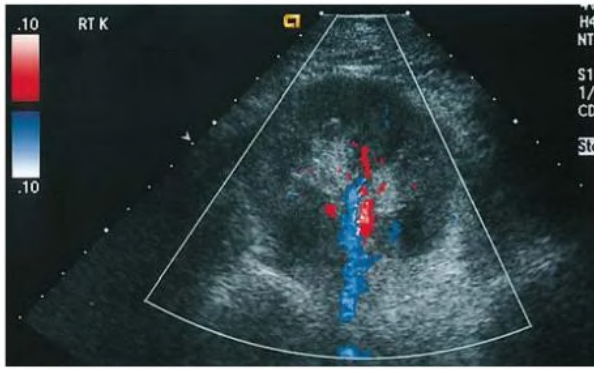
Transverse color Doppler ultrasound evaluation of the kidney shows the artery as red and the vein as blue.
